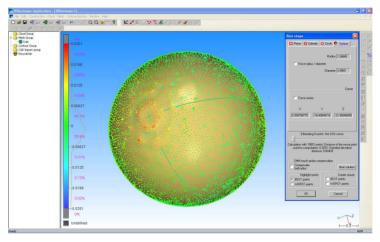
Mapping deviations of the surface of a ceramic reference ball resulting from the errors of measurement of the radius performed on computer tomography – a view in the polar axis of the CT.
